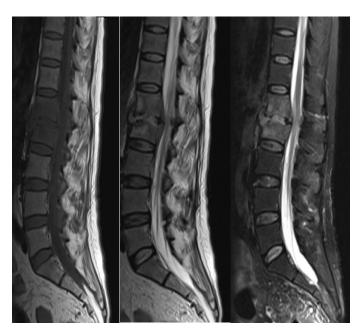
Lumbar MRI in sagital plane: T1 (left), T2 (middle) and STIR (right) showing L1 and L2 osteomyelitis, L1-L2 discitis, epidural abscess and cauda equina compression
